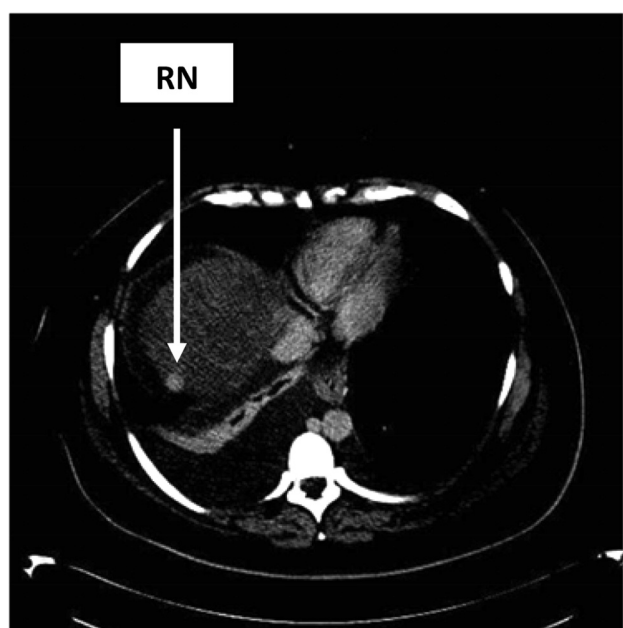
A benign hypervascular regenerative nodule (RN) on a transverse CT-scan.
